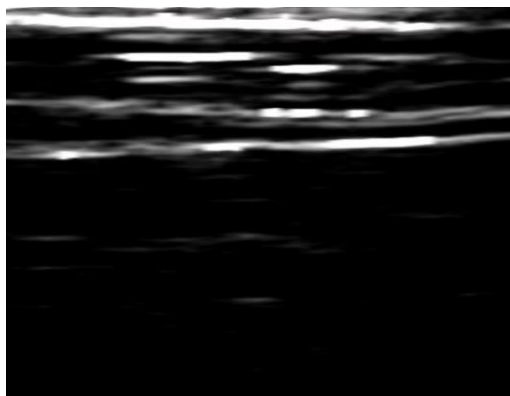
High-frequency (40 MHz) ultrasound image of a single renal sympathetic nerve fiber
